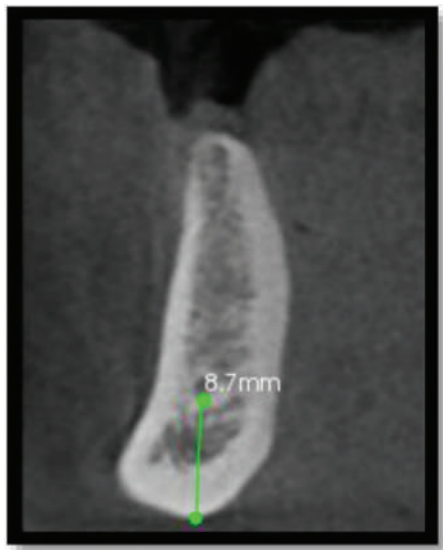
CBCT images of distance from mental foramen to the lower border of the mandible. CBCT, cone-beam computed tomography
